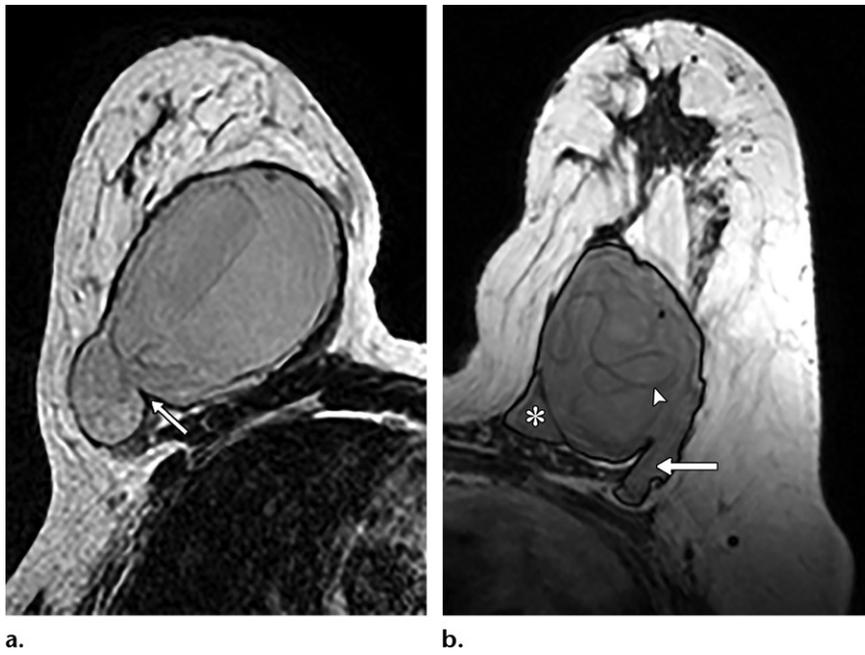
Implant contour abnormalities at MR imaging. (a) Axial T2-weighted MR image of the right breast demonstrates herniation along the posterolateral aspect of the silicone implant. Herniations typically extend further outside the expected contour of the implant and often create acute angles (arrow) at the neck of the protrusion. (b) Axial T2-weighted MR image of the left breast shows a posteromedial bulge (*) and a posterolateral herniation (arrow). The linguine sign indicating intracapsular rupture (arrowhead) is also seen.
